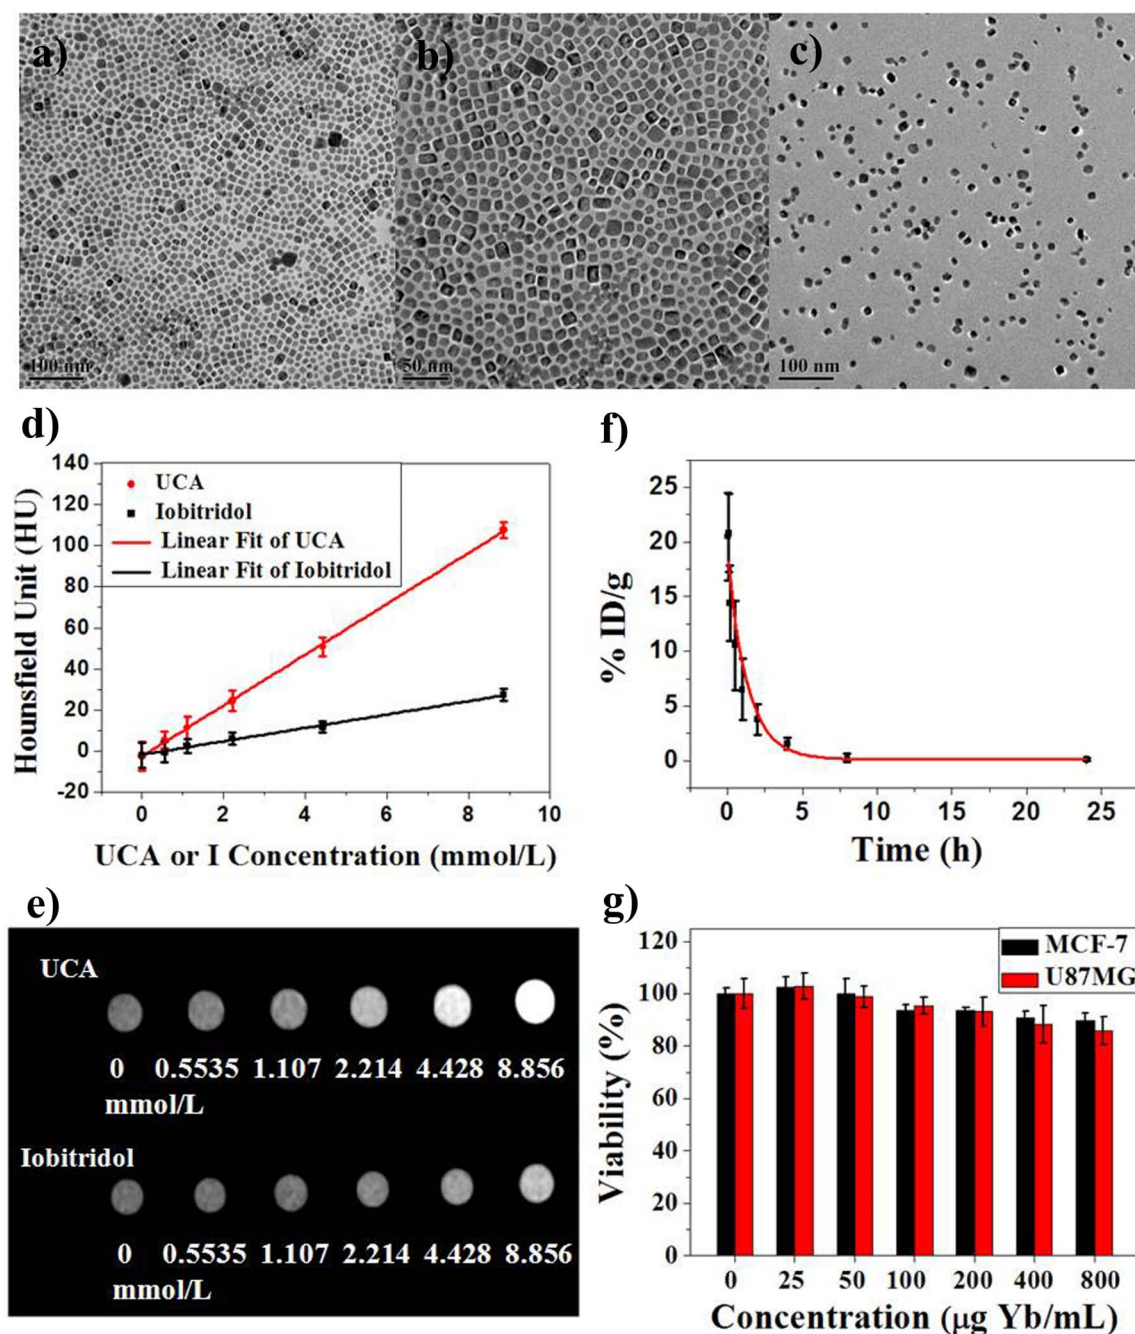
(a, b) TEM images of OA-BaYbF₅:2% Er³⁺ nanocubes in chloroform; (c) TEM images of RGD-labelled UCA in water; (d) CT values and (e) images of UCA and Iobitridol with different concentrations; (f) *In vivo* blood terminal half-life (t_{1/2}) of UCA-RGD *in vivo* (n = 3) and (g) Cell viabilities of U87MG and MCF-7 cells incubated with UCA-RGD of different concentrations for 24 h.
